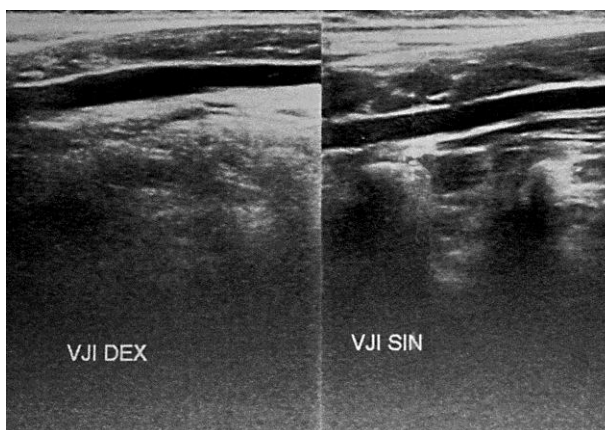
Control ultrasound imaging of the internal jugular veins six weeks after therapy completion.
